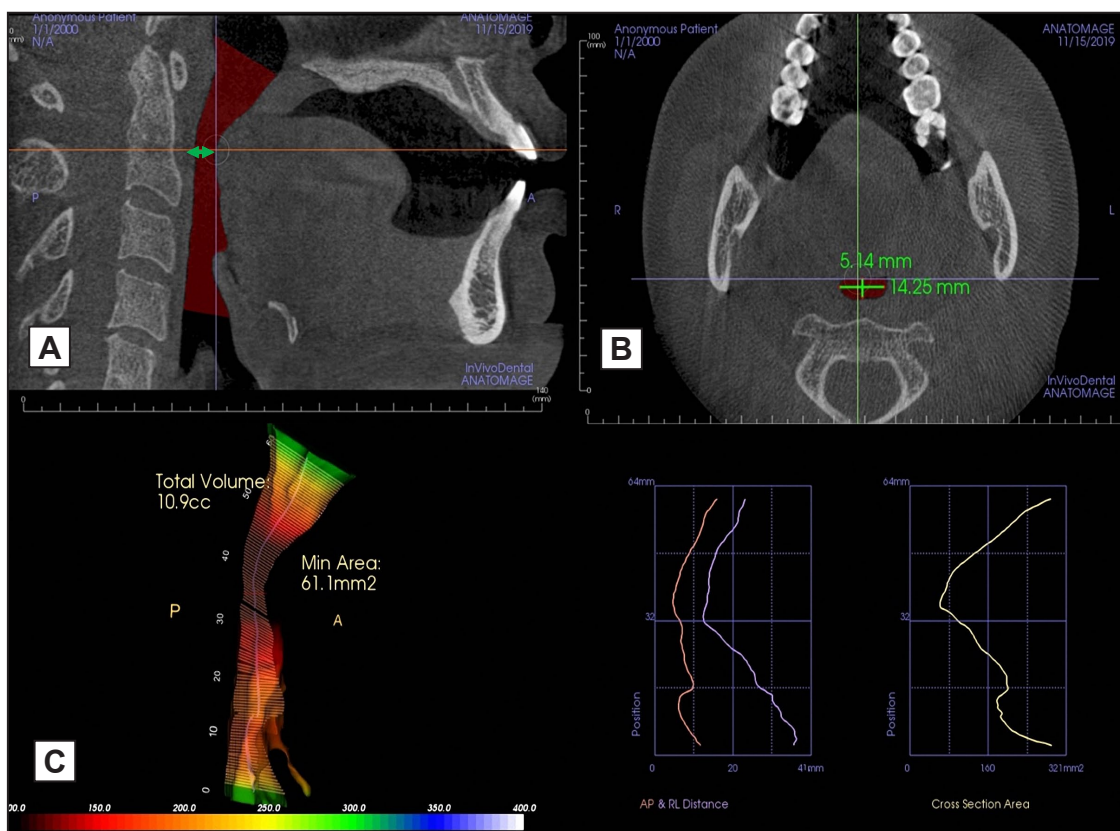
Airway analysis was conducted on cone-beam computed tomography scans with Invivo™ software. A = on sagittal view, the most constricted point of oropharynx was identified manually, as marked by the green double-headed arrow. B = on the corresponding axial view, the minimal anterior-posterior (AP) and mesial-lateral (ML) dimensions of oropharynx were measured using linear measurement tools of Invivo™ software, as AP = 5.14 mm, and ML = 14.25 mm. C = total airway volume (10.9 ml) and minimal surface area (61.1 mm²) were automatically calculated by the software.
